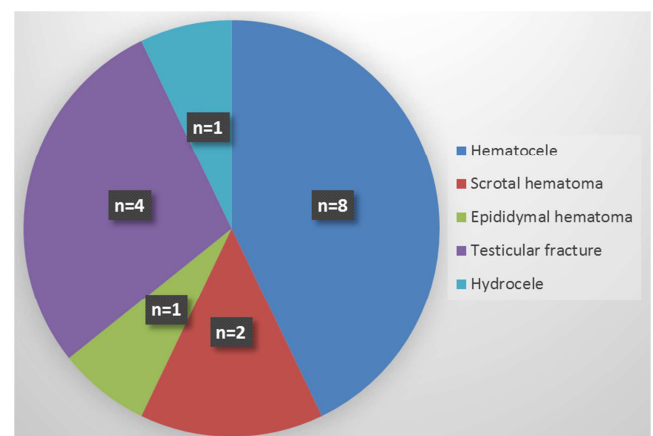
Ultrasound lesion distribution.
